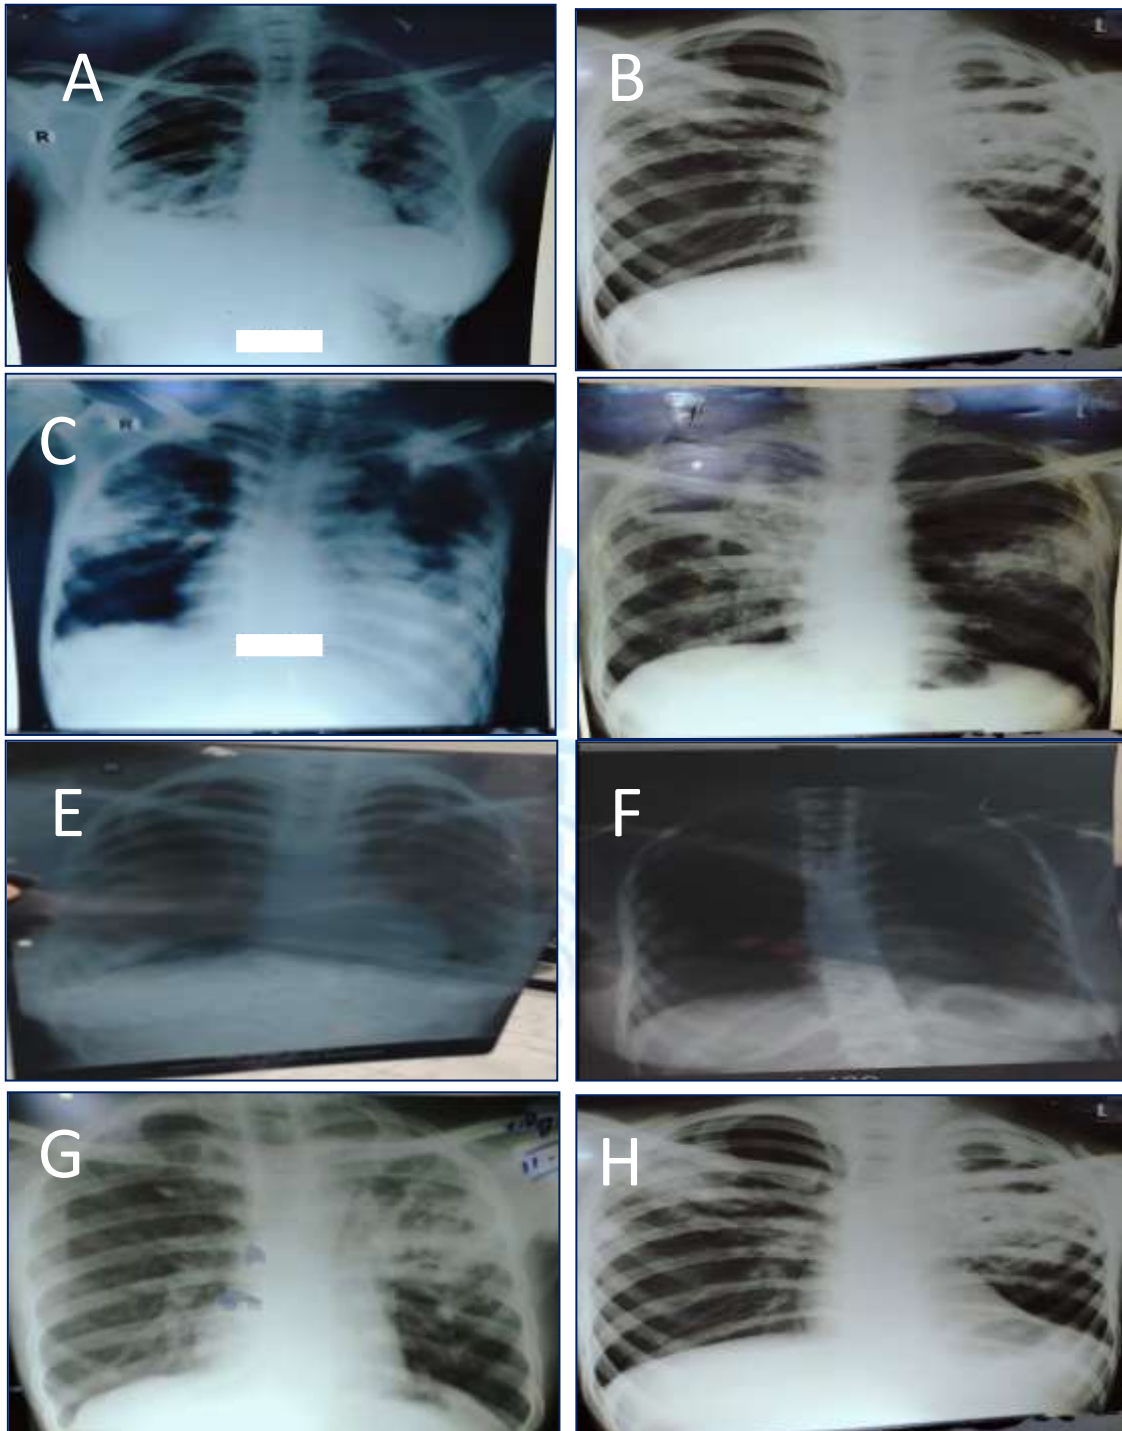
Chest X-ray findings in patients with suspected tuberculosis
